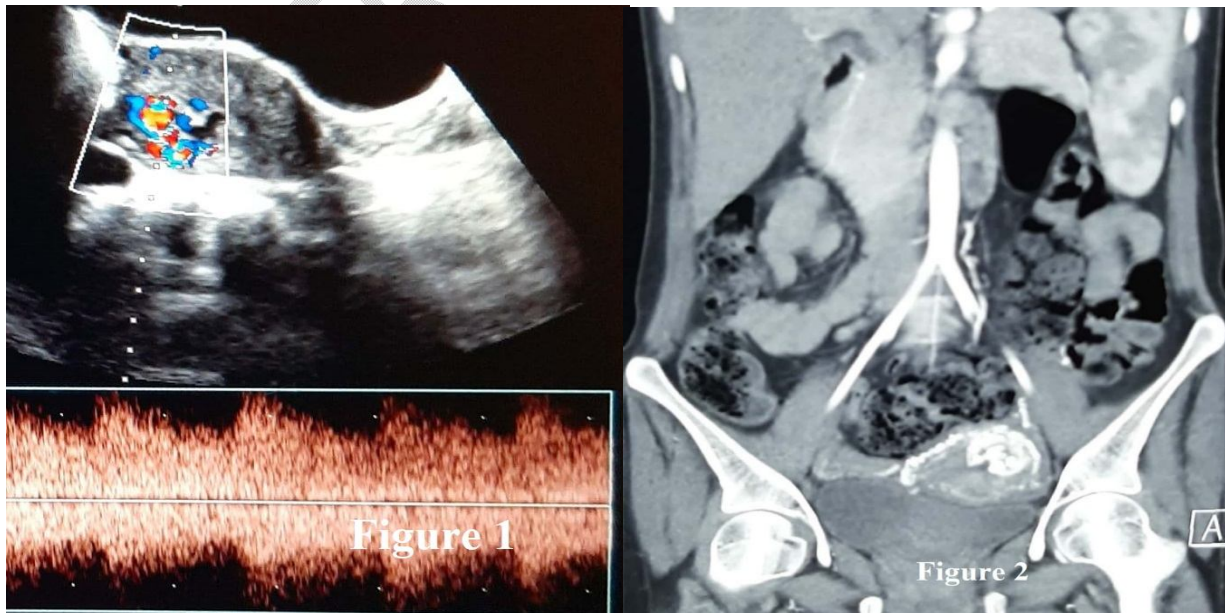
Ultrasound showing bulky uterus with prominent vascularity in posterior wall.
